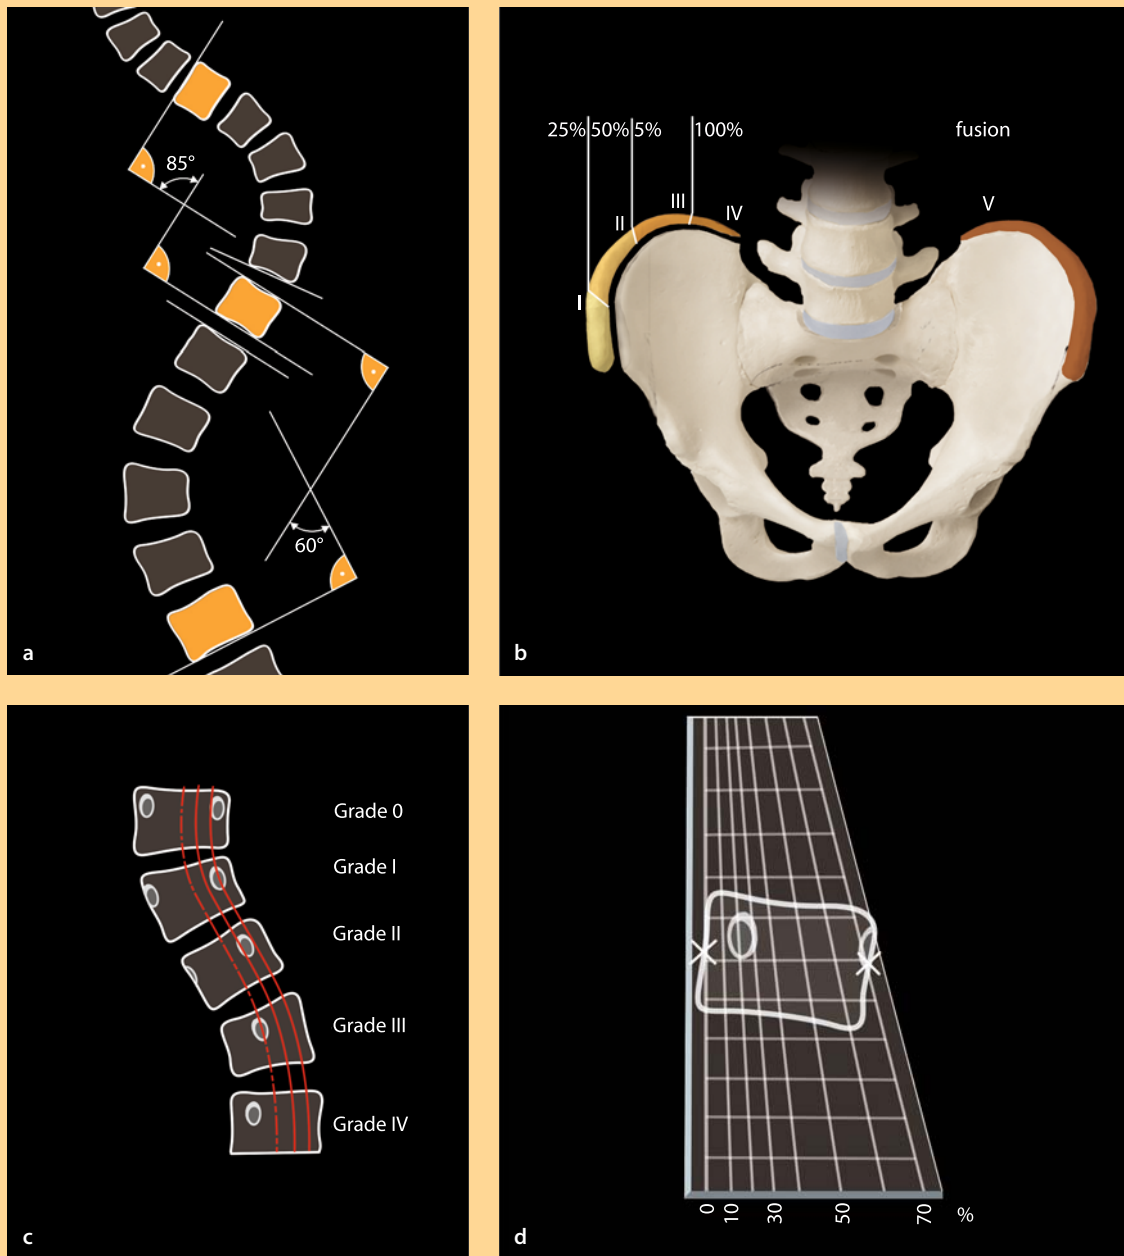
Radiographic assessments
